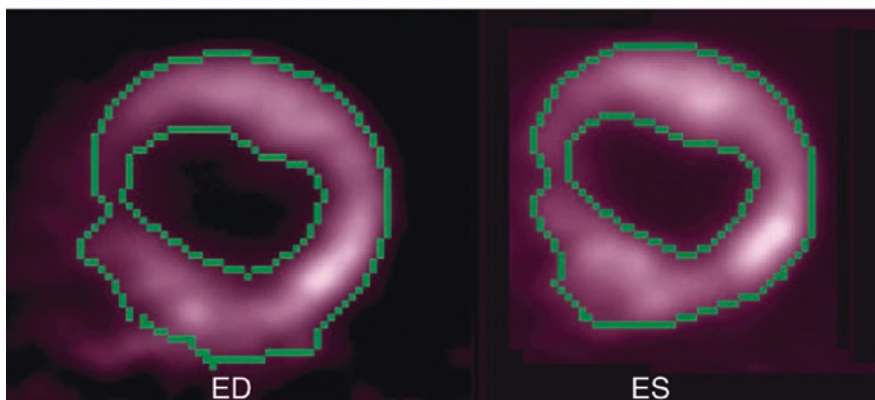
Gated myocardial perfusion images. This sequence shows the gated set of eight images obtained from imaging a tracer that labels the myocardium, in this case ^{18}F -fluorodeoxyglucose (FDG). The small number of images and reduced sampling rate tends to slightly blur true end systolic (ES) with late systolic and early diastolic data, overestimating ES volume and underestimating ejection fraction. However, it has
